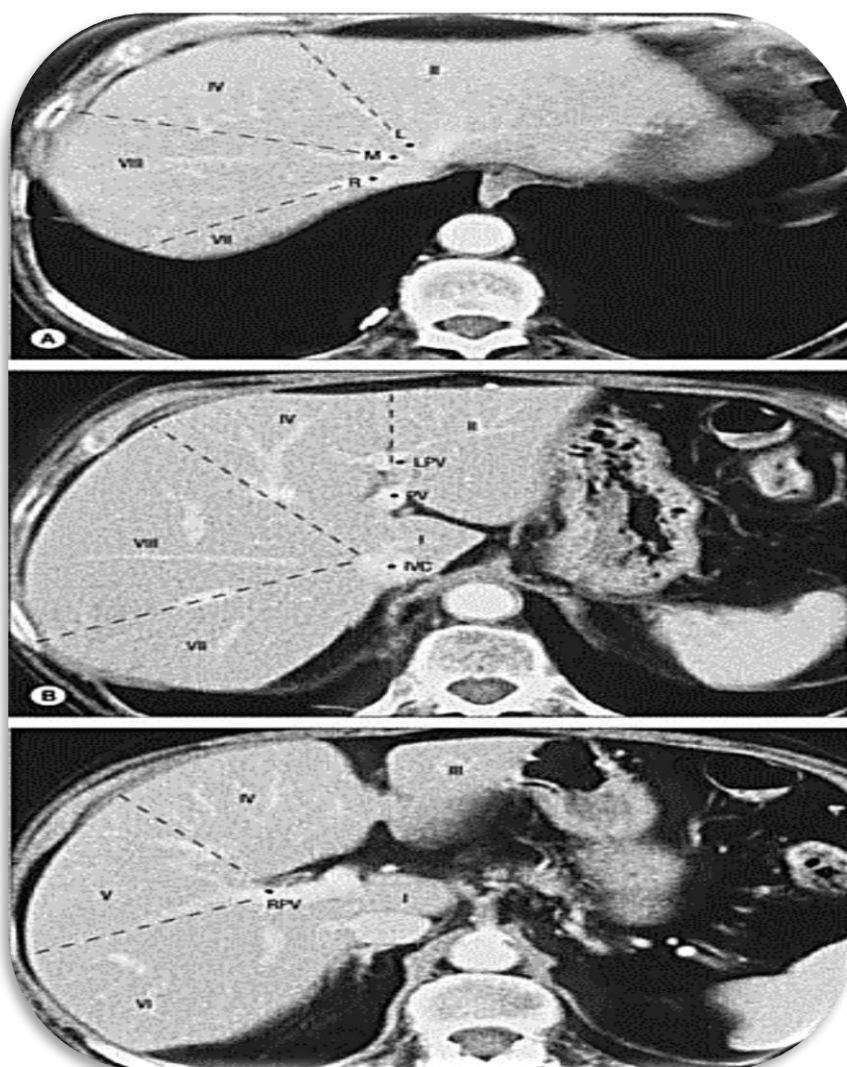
Segments of the liver seen on axial CT scan. A, Contrast enhanced CT shows the left (L), middle (M), and right (R) hepatic veins at the superior aspect of the liver marking the left main and right portal fissures. B, Inferior to this the caudate lobe (segment I) lies between the inferior vena cava (IVC) and the main portal vein (PV). The left portal vein (LPV) separates segment II superiorly from segment III inferiorly. C, The right portal vein (RPV) divides segments V and VI inferiorly (C) from segments VII and VIII superiorly (B). (*Oliveira et al., 2011*)
